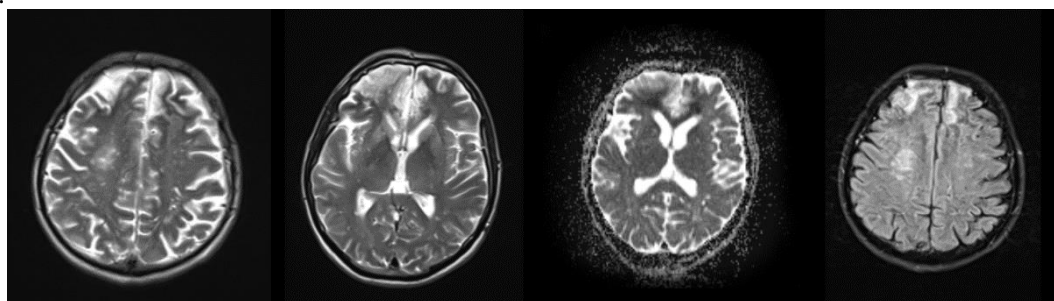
MRI scan of the brain showing bilateral extensive hypersignal areas in the parasagittal frontal cortical, peri and supraventricular regions, with restriction of diffusion.
